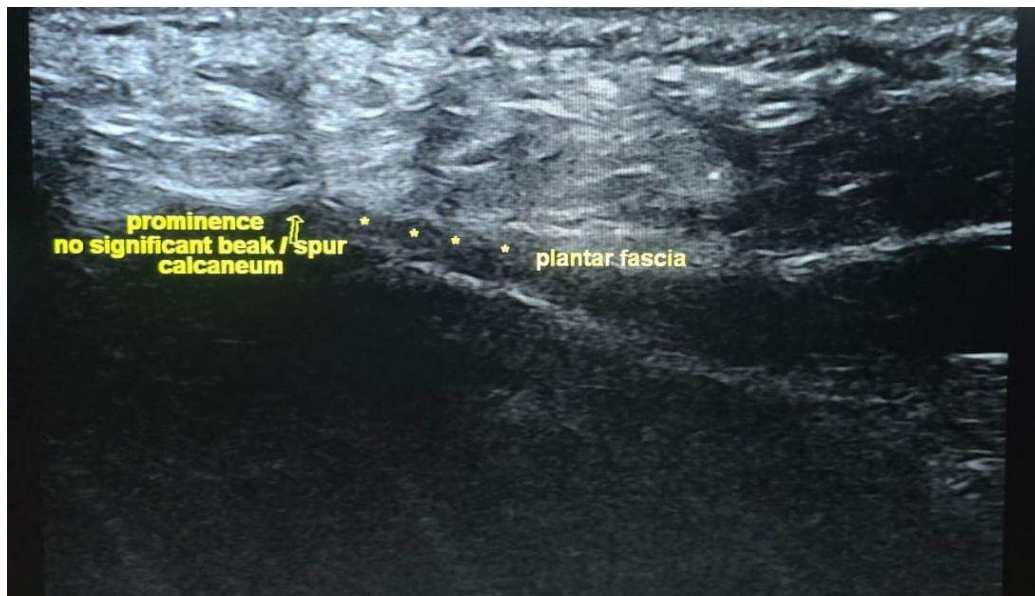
After treatment of shock wave therapy, the ultrasographic findings show plantar fascia (PF) thickness was reduced to 3.0 mm on the right side.
